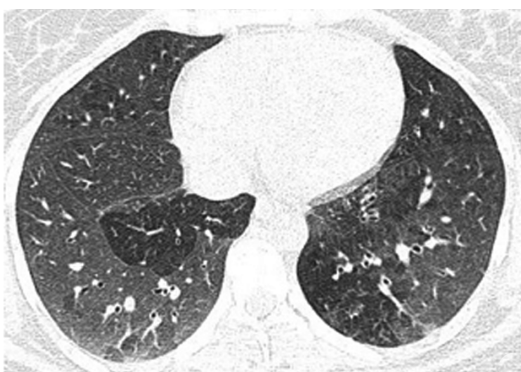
Axial HRCT slice at the level of the lower lobes, obtained during the expiratory phase, showing bilateral areas of mosaic attenuation, as well as a well-defined area of air trapping in the lower lobe of the left lung.
